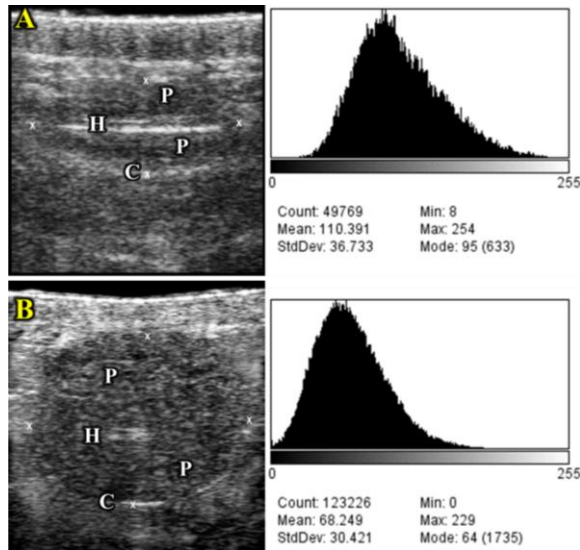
Ultrasonographic examination of supramammary lymph and its corresponding gray scale histogram analysis; in normal (A) and in subclinical mastitis (B). Showing the lymph node capsule (C), parenchyma (P) and hilar area (H)
